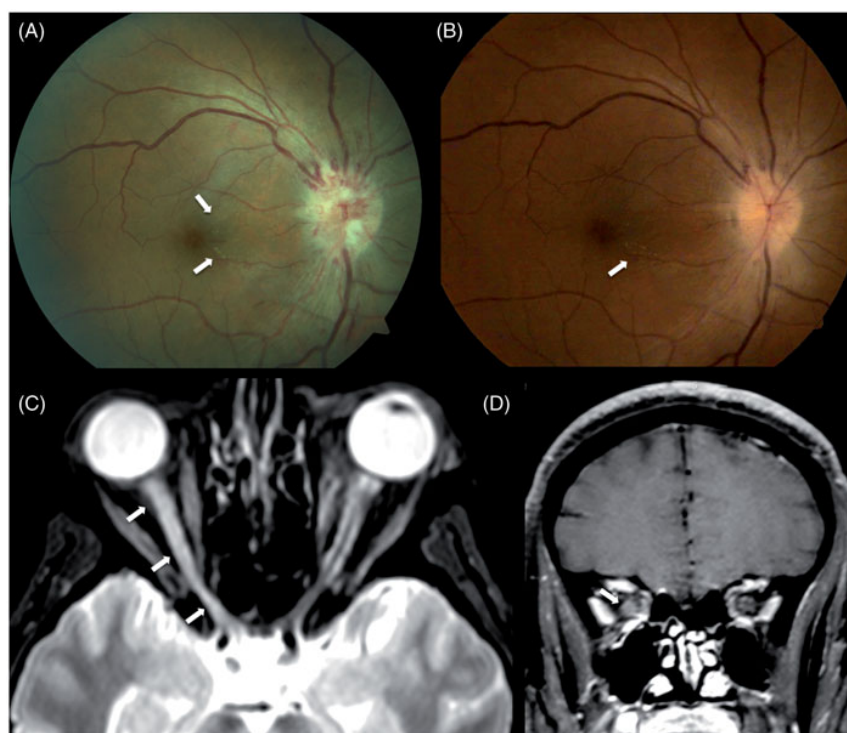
(Upper panels) Colour fundus view of right eye at admission (A) shows optic disc oedema with macular star (arrows) and (B) remarkable improvement of the optic disc oedema and macular star (arrow) 10 days after treatment. (Lower panels) Orbital magnetic resonance imaging shows a (C) T2-weighted hyperintense extensive lesion (arrows) in the right optic nerve with T1-weighted sequence contrast enhancement (D; arrow).
